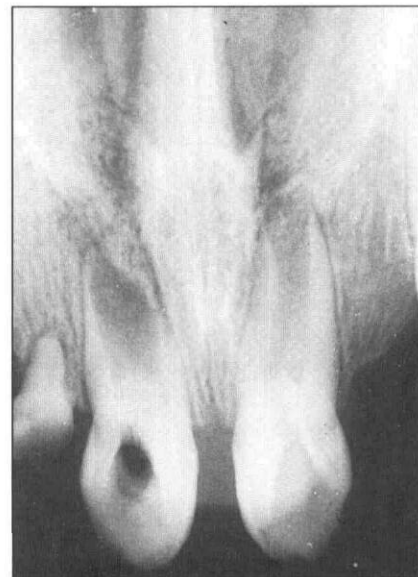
Periapical radiograph of the premaxilla region of Case 1. Notice the deep dens invaginatus in both incisors and the missing permanent lateral incisors.
